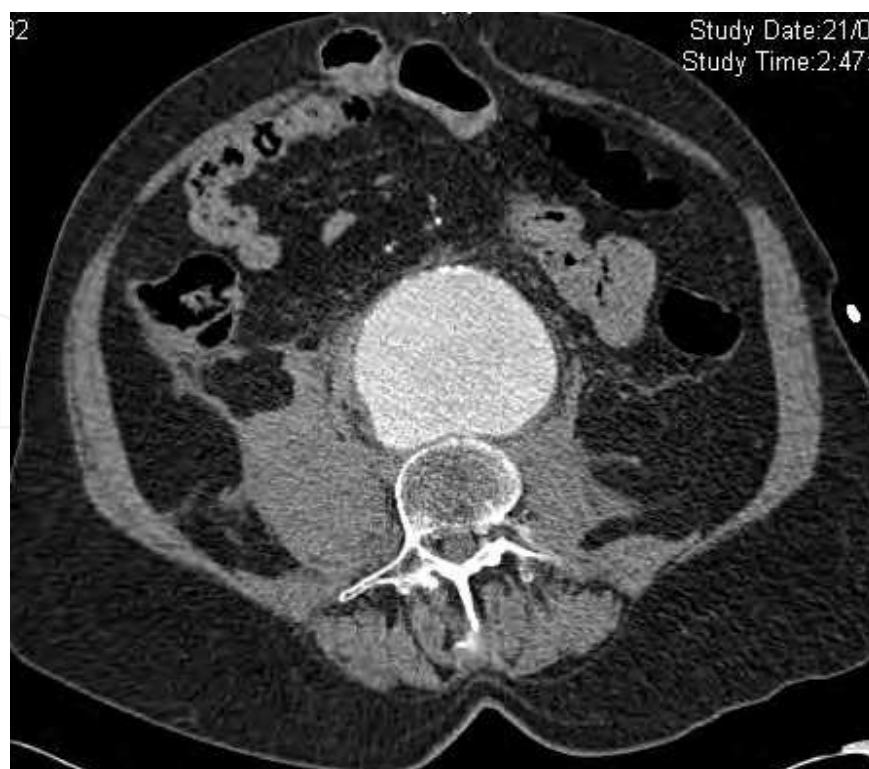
A. CT scan of a contained ruptured AAA
